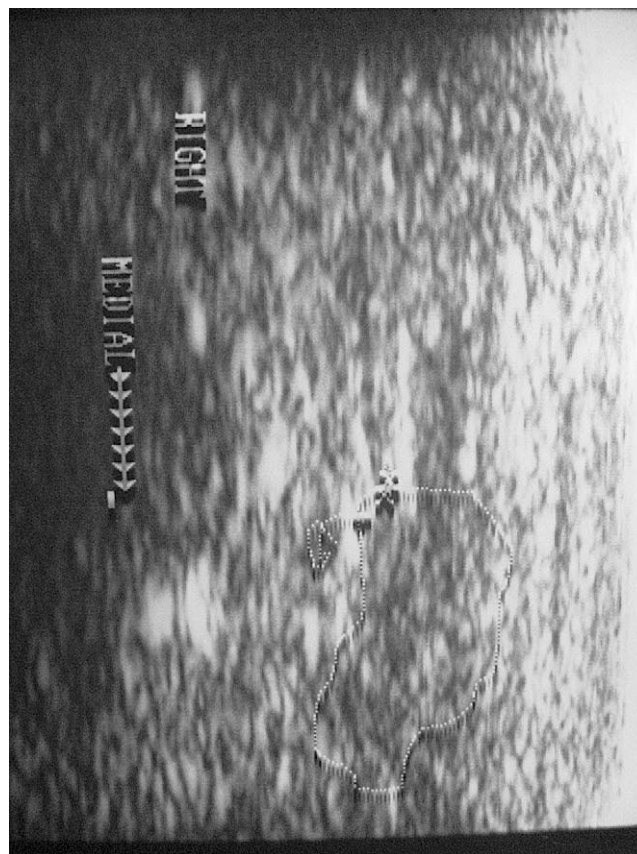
Diagnostic ultrasound image of the plantar soft tissue mass localized to the fat pad of the heel. Note the hypoechoic mass (outlined), consistent with neuroma formation.
